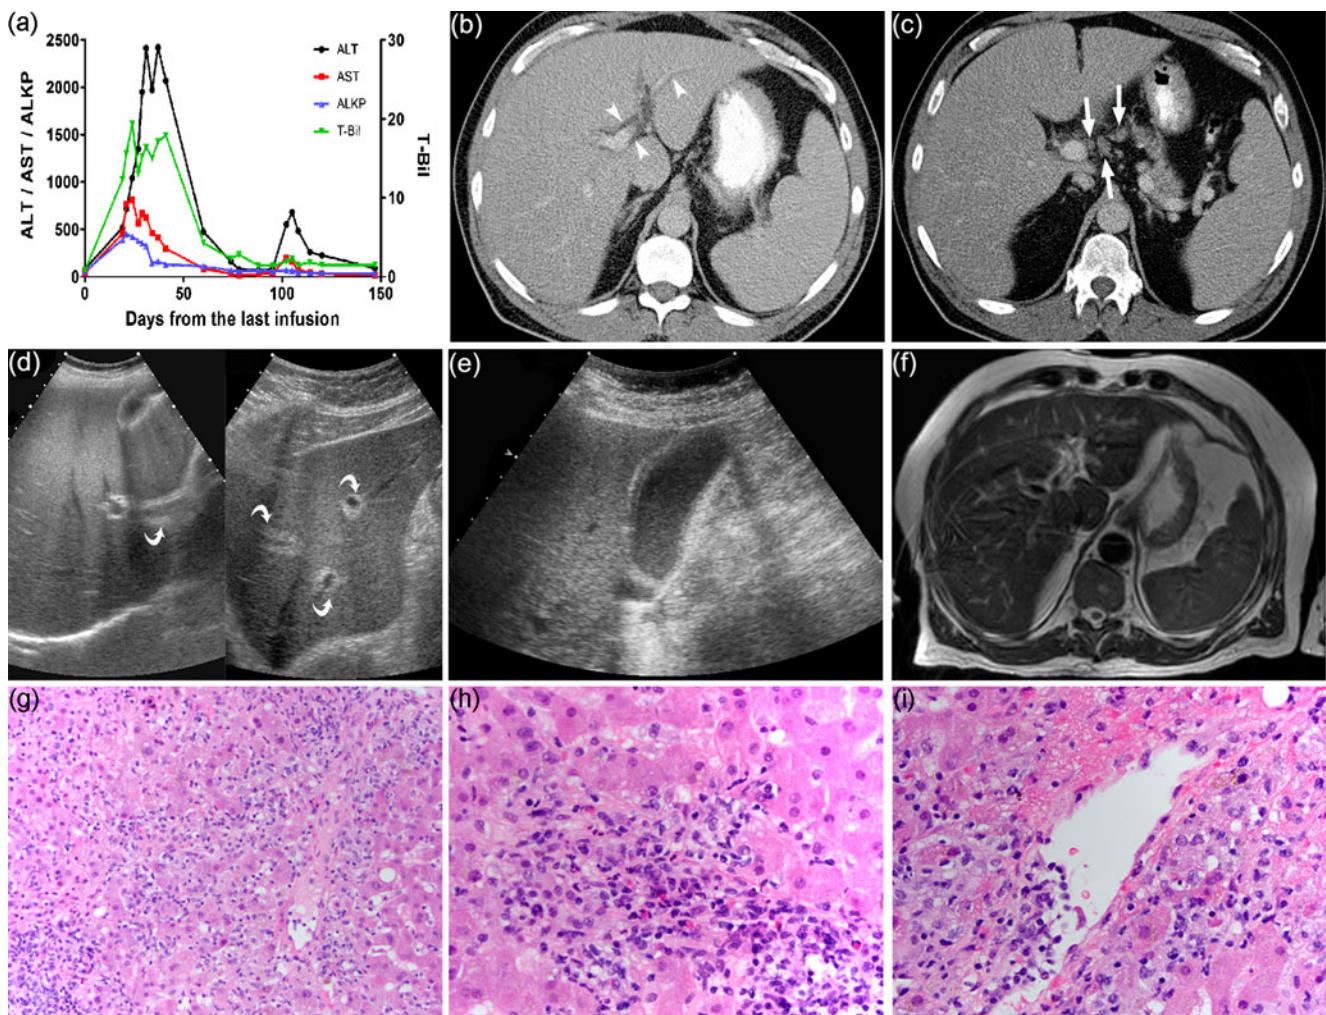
Sixty three year-old man with fever, nausea and increased LFTs during ipilimumab treatment (case 1). a Profile of LFTs. Note the double peaks of LFT abnormalities during steroid treatment. b, c Axial contrast-enhanced CT images. The size of liver and spleen are increased from prior CT (not shown). New periportal edema [arrowheads on (b)] and multiple periportal enlarged lymph nodes [arrows on (c)] are present. d, e Ultrasonography images demonstrate prominent hyperechogenicity of portal vein wall and periportal space [curved arrows on (e)] and layered gallbladder wall thickening likely representing gallbladder wall edema (f). f
